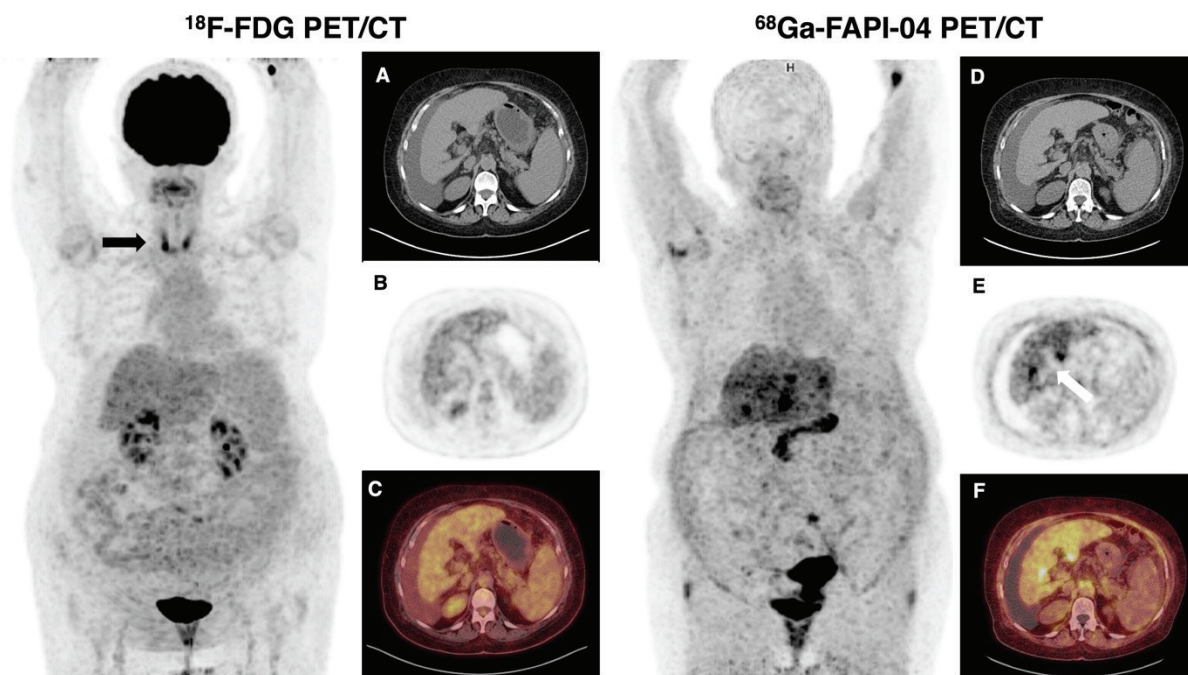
¹⁸F-FDG and ⁶⁸Ga-FAPI-04 PET/CT scans were obtained on a 70-year-old woman patient with free fluid in the peritoneum for the evaluation of liver cirrhosis [(A, D) CT]. Slightly increased tracer activity in the liver [(B) PET, (C) fusion images] and diffusely increased thyroid uptake (arrow) indicated thyroiditis were seen on ¹⁸F-FDG PET/CT. The axial view of PET (E) and fusion images (F) showed intense heterogeneous FAPI uptake (SUV_{max} : 9.7) in the liver, but no FAPI uptake in the thyroid gland on ⁶⁸Ga-FAPI-04 PET/CT.
